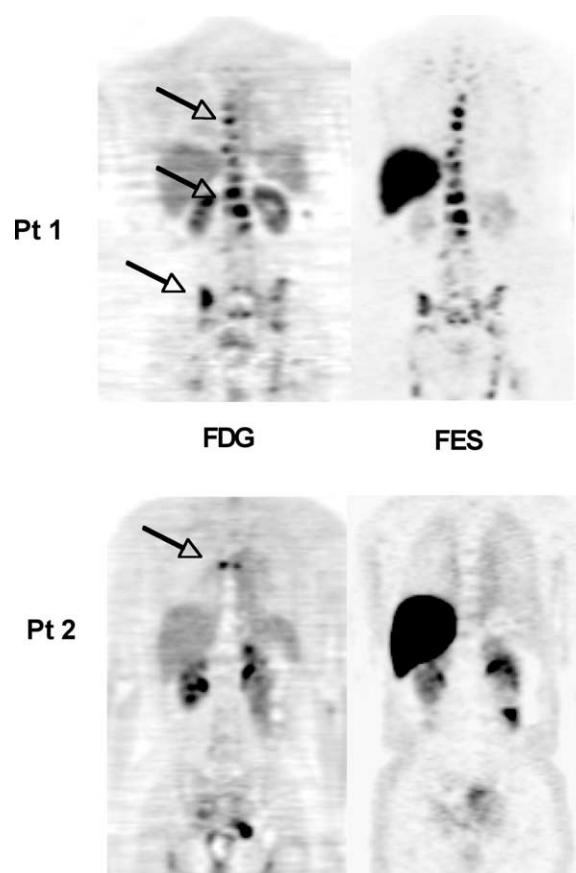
FES-PET imaging predicts response to hormonal therapy. FDG (left) and FES (right) coronal PET images through the spine and pelvis are shown for 2 patients with breast cancer bone metastases from ER+ primary tumors. Both were treated with aromatase inhibitors, and FDG and FES-PET studies were obtained close to the start of treatment. Patient 1 (top row) had extensive bony disease involving the T-spine, L-spine, and pelvis, seen clearly on FDG-PET (arrows) and showing high uptake of FES. This patient had an excellent response to therapy, as indicated by improved symptoms and improvements on imaging studies, including FDG-PET. Patient 2 (bottom row) had relatively small-volume T-spine disease seen on FDG-PET (arrow), but not on FES. The patient subsequently had disease progression documented by multiple modalities.
